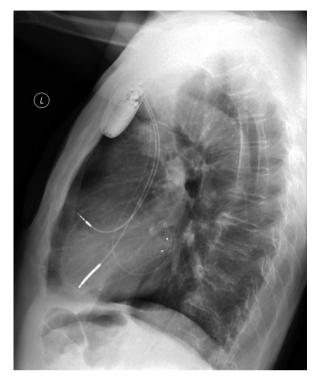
The lateral chest X-ray taken after TLE procedure
